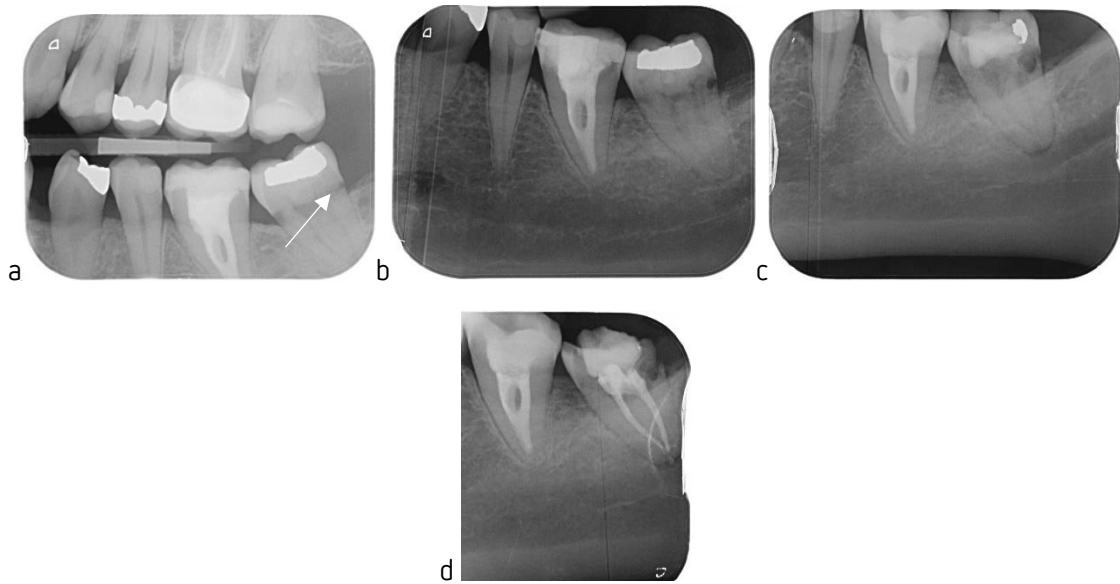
image a)* routine bitewing, arrow indicates external root resorption, diagnosed as carious lesion of tooth 37
